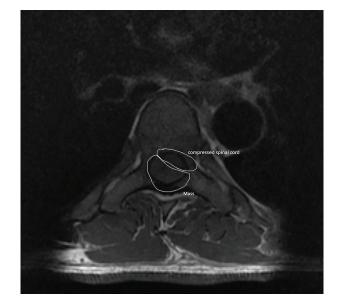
MRI spine axial view showing the mass compressing the spinal cord.
